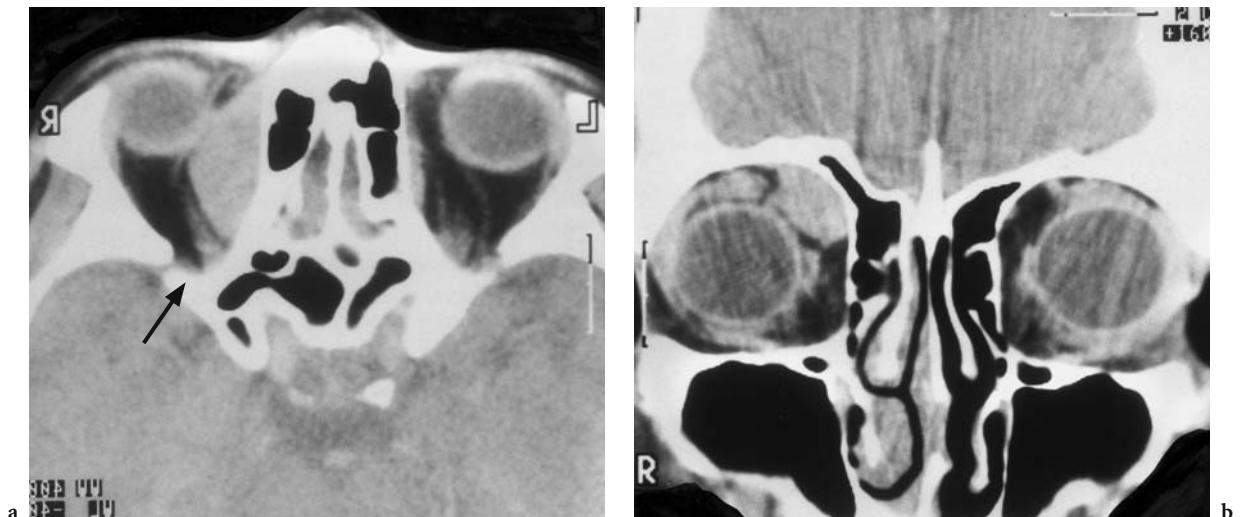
A 32-year-old man with double vision. Diagnosis: lymphoma of the right superior oblique muscle as the first manifestation of generalized lymphoma. CT: a Axial view with a sharply defined, tumor-like mass in the right superior medial orbit and slight impression of the proximal part of the superior rectus muscle (*arrow*). Note the small size of the superior ophthalmic vein visualized in both orbits. b Coronal view showing additional involvement of the superior oblique muscle. (With permission of MÜLLER-FORELL 1998)
